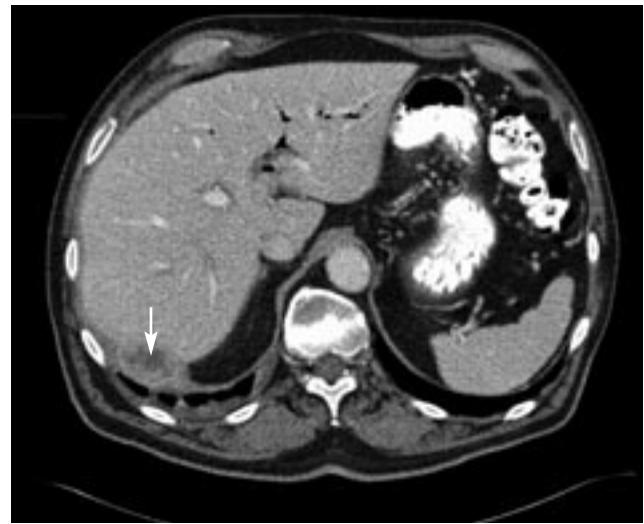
Computed tomography scan of the pelvis with contrast shows a possible hepatic lesion (arrow).
